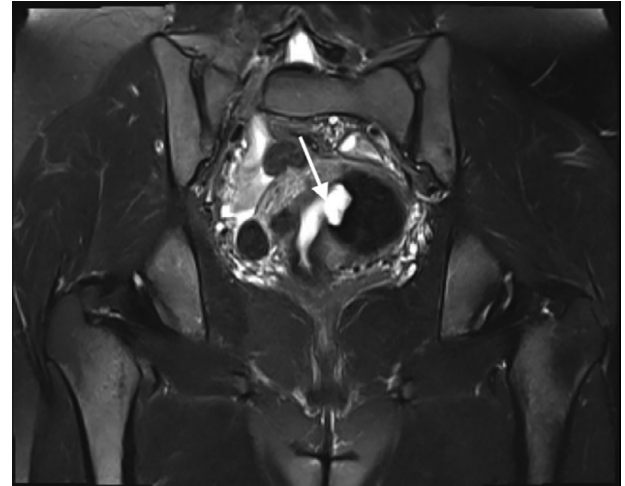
Postembolization state (2018) T2-weighted MRI coronal fat saturated view shows decreased size of myoma and connection to endometrium compare to Figure 3.
